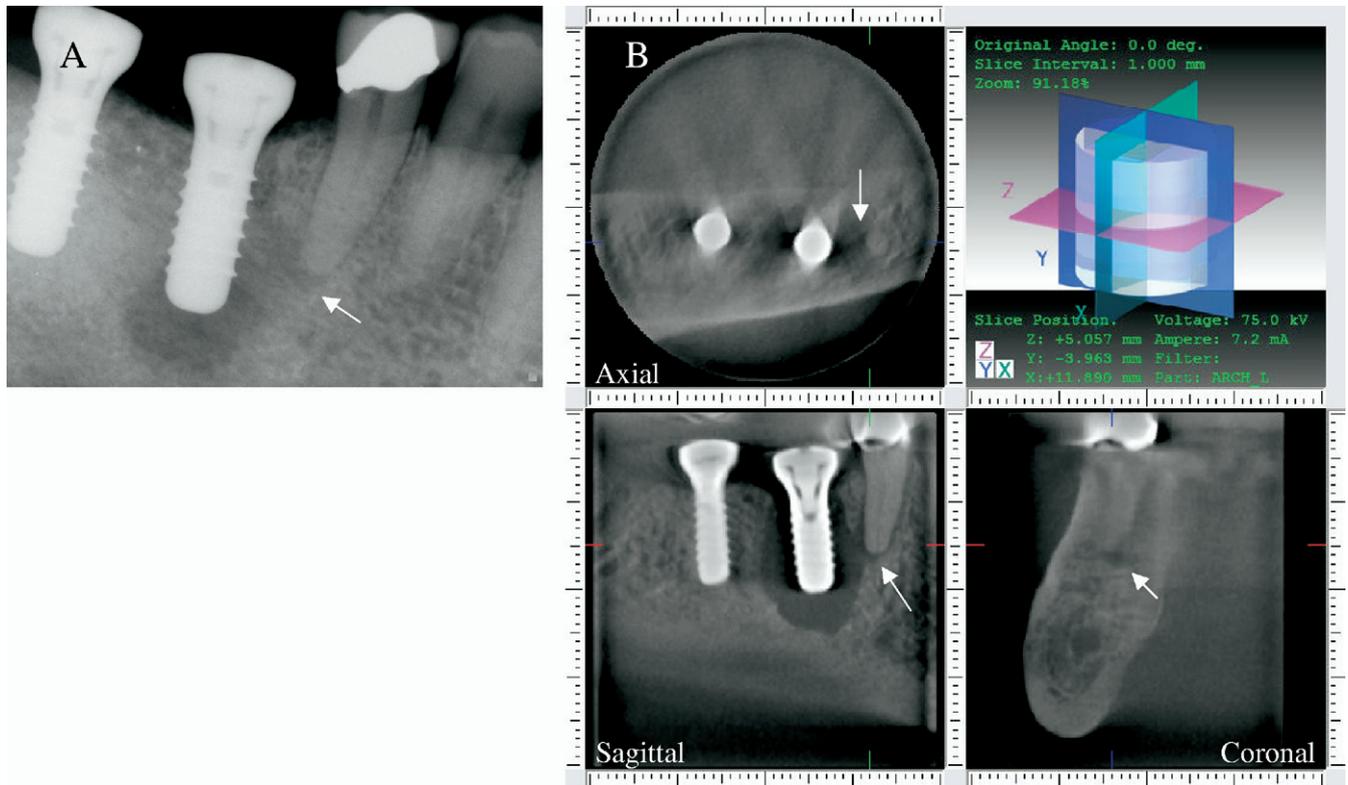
(A) Periapical radiograph demonstrates an extensive PIL and its proximity to the apex of #29. (B) CBVT shows axial, sagittal, and coronal 2-D slices of the PIL in relation to the apex of #29.
